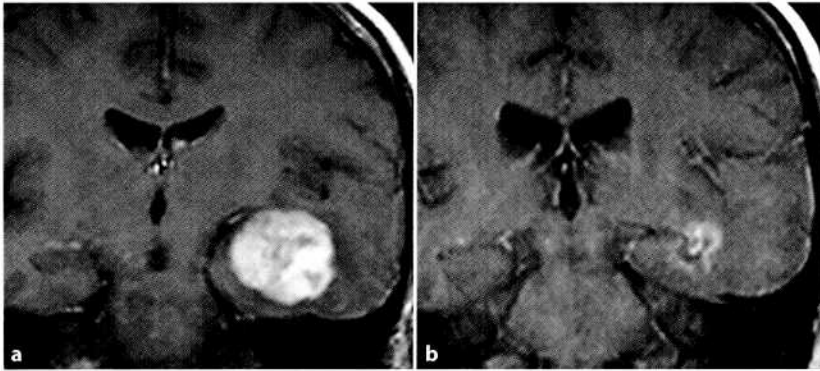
a Left temporal metastasis at the time of Cyberknife treatment (magnetic resonance T₁-weighted Gd-enhanced) b Follow up-study with magnetic resonance image after 9 months: remission of the treated metastasis with some reactive contrast uptake.
